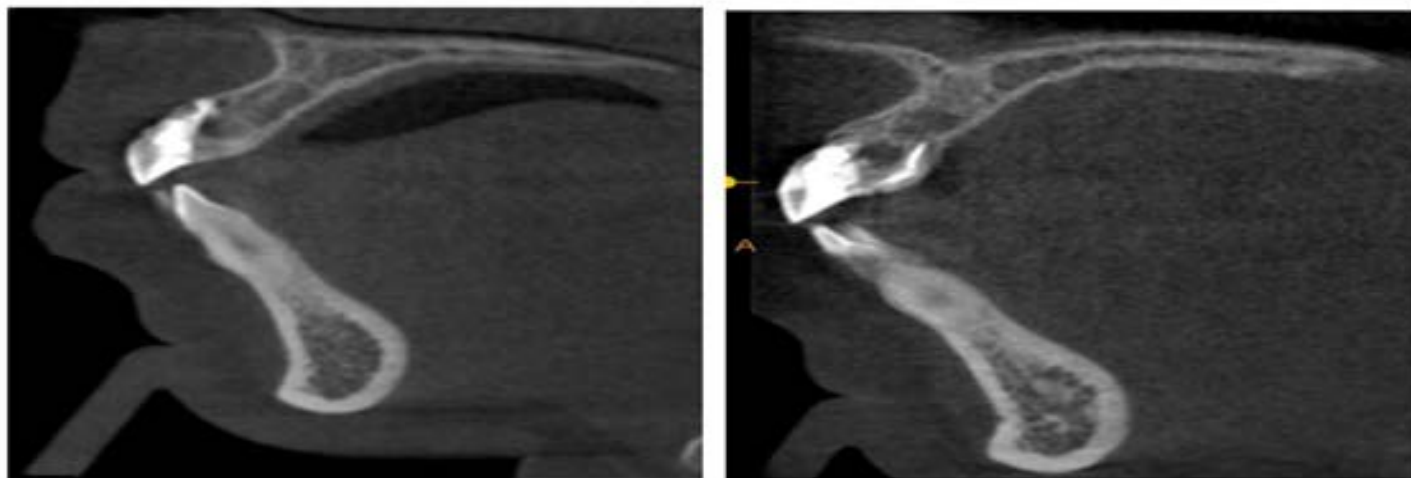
CBCT image of 21 showing (a) MTA obturation with buccal root (b) Palatal root obturation using gutta percha
